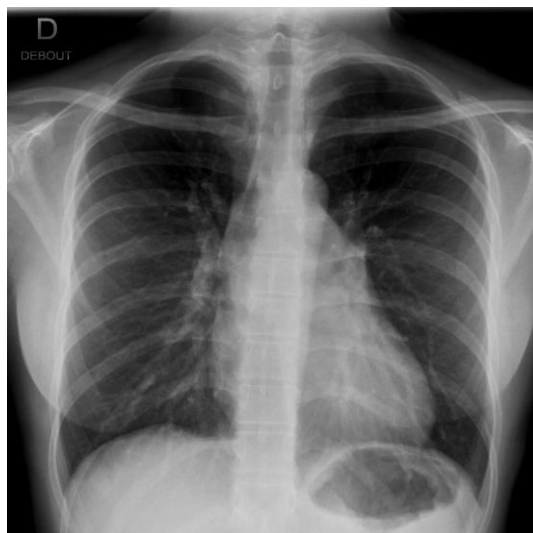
A large mediastinal enlargement associated with a solitary fibrous tumour of the pleura is clearly visible on frontal chest X-ray (a). However, more subtle is the deviation of the left paravertebral line (red arrows) which is better appreciated on coronal CT scan with MPVR reformatting (slice thickness: 32 mm) (b). This deviation is linked to a second tumour, visible on axial CT scan in mediastinal window (c). When carefully analyzed, the deviated paravertebral line converge towards the spine below the level of the diaphragmatic cupola, confirming the thoracic origin of the lesion (negative thoraco-abdominal sign, described later).
